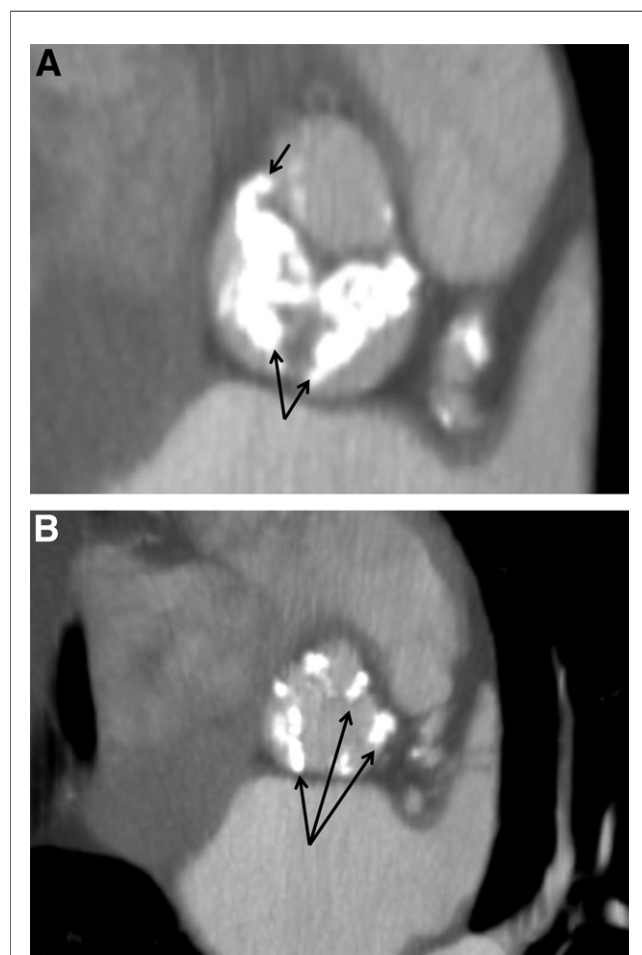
CT Scan Demonstrating Distribution of Calcium on the Aortic Valve
